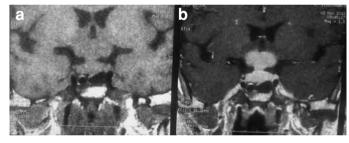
MRI of sella turcica. (a) Sagittal section, T1-weighted images showing involvement of pituitary gland, infundibulum and optic chiasm by leukemic infiltration, and loss of hyperintense signal of the posterior pituitary. T1-weighted post gadolinium enhanced MR images show a contrast-enhancing thickened pituitary gland, stalk and optic chiasm. (b) Coronal section, T1-weighted images and post gadolinium enhanced MR demonstrating enlarged pituitary gland, optic chiasm and stalk
